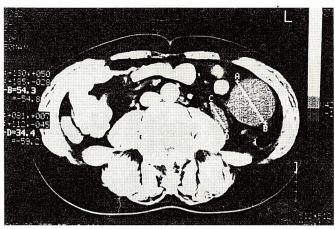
CT scan showing double fluid-filled masses without discernible wall located in the retroperitoneal region and involving the mesentery of the sigmoid colon.
